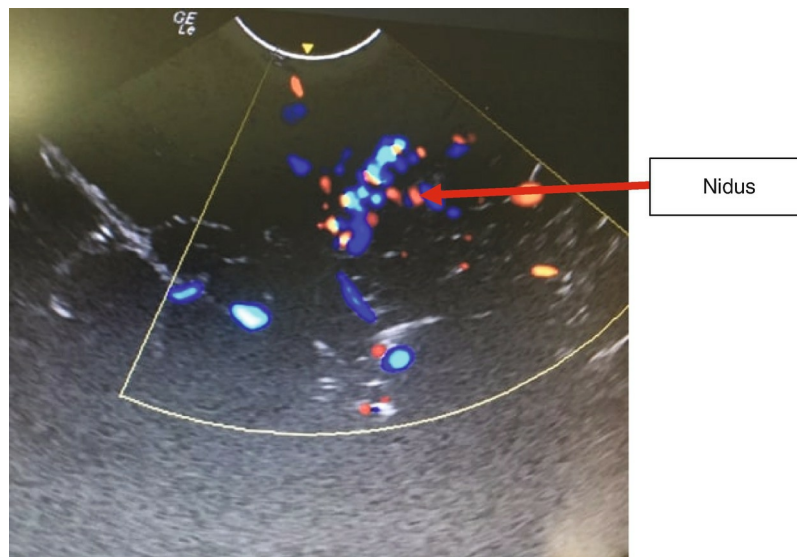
Intraoperative ultrasonography showing nidus
